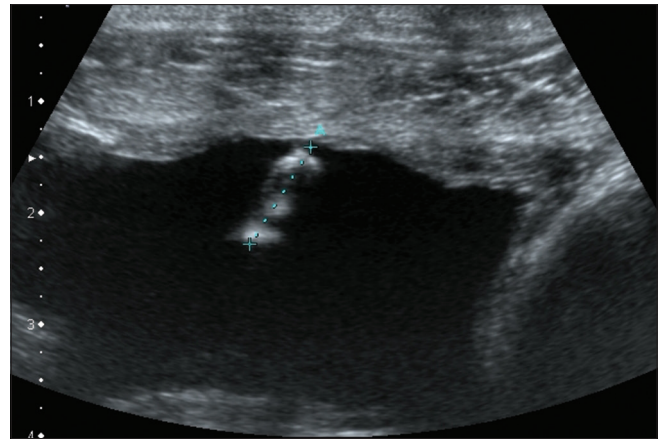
Tissue mass suspended from the anterior bladder wall, vascularized on Colour Doppler, associated with thickening of the bladder wall in keeping with infiltration
